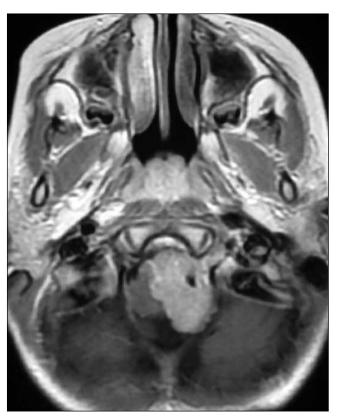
Preoperative contrast-enhanced axial T1-weighted MR image shows envelopment of the left vertebral artery.
